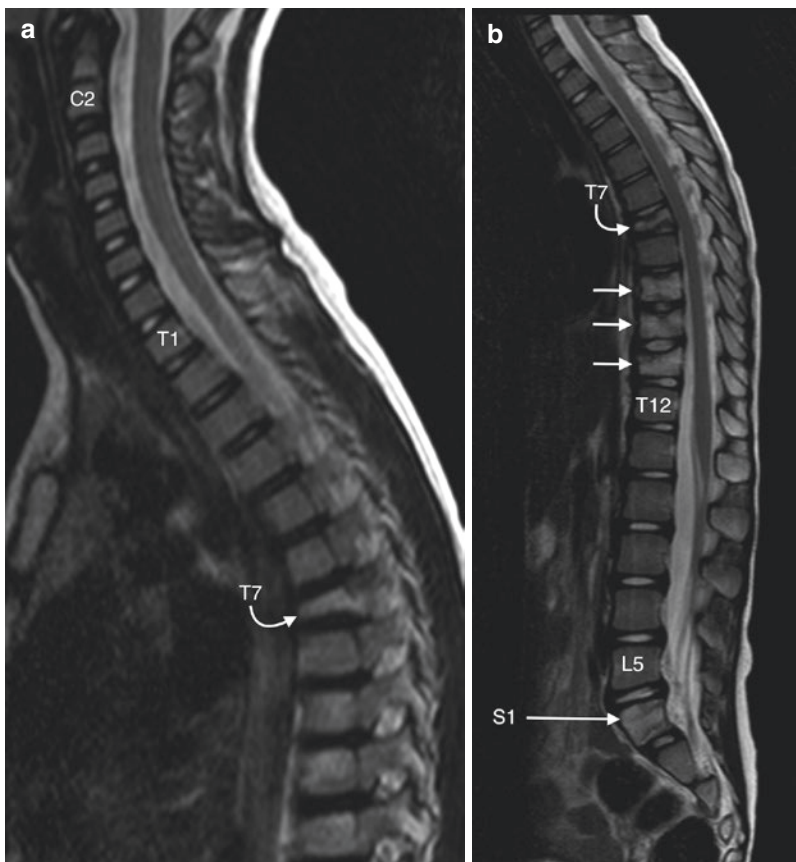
Counting and labeling thoracic vertebral levels can be performed with scout MR or CT images or with fluoroscopy. This becomes particularly important when dealing with subtle thoracic lesions or when sampling thoracic disks. T2-weighted sagittal scout image (a) of the cervical and upper thoracic spine; C2 and T1 are labeled and a partial
